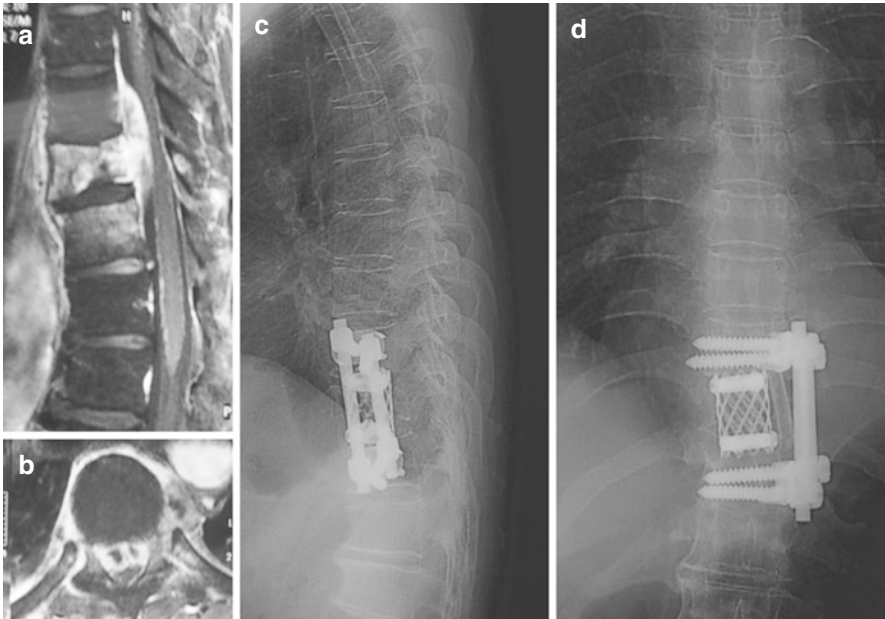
(a, b). T1-weighted sagittal and axial contrast MRI showing the subligamentous spread of abscess in TB spine. (c, d) Standing lateral and anteroposterior radiographs after anterior radical debridement, fusion by titanium mesh cage packed with autogenous bone graft, and anterior instrumentation. There is no contraindication for applying metallic implants in TB
